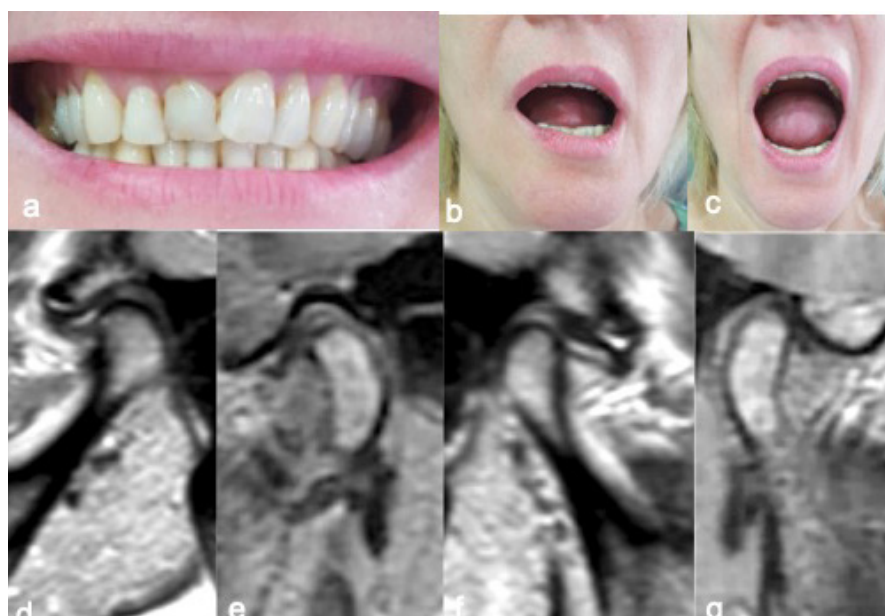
Case one. (a): The patient presented an increased overbite; (b): Mandibular pre-treatment opening was slightly restricted probably due the muscle restriction caused by the intracapsular derangement; (c): The functional post-treatment examinations confirmed that the objectives of the treatments were to eliminate the pain and sound, the mandibular opening is normal and without deviations; (d, f): Pre-treatment MRI image showed both disc anteriorized, with a worst position on the left TMJ; (e, g): Post-treatment imaging showed a recover of good condyle-disc position on the right side (g), while the left TMJ the disc results yet anteriorized, but very thickened in the retrodiscal zone (e).
